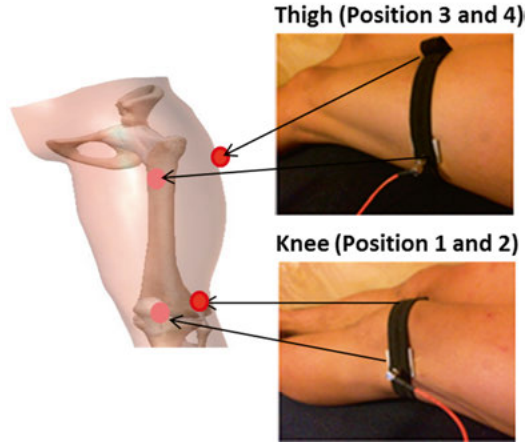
The proposed microwave sensor connected to the two positions of the distal femur and the thigh with a coaxial cable. . © 2018 Sensors. Reprinted, with permission, from [Mohd Shah, S.R., Velandar, J., Mathur, P., et al. Split-ring resonator sensor penetration depth assessment using in vivo microwave reflectivity and ultrasound measurements for lower extremity trauma rehabilitation, Sensors, Feb. 2018].⁹⁴
